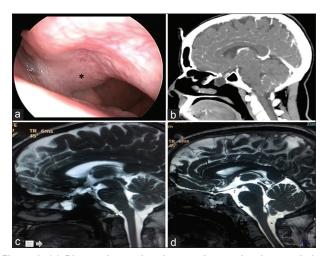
(a) Diagnostic nasal endoscopy image showing persisting embryonal infundibular recess presenting as a nasal mass in the superior nasopharynx (*). (b) Contrast computed tomography brain showing a cystic lesion herniating through a bony defect anterior to shallow sella. (c) Preoperative magnetic resonance imaging constructive interference in steady state sequence showing the communication of the third ventricular floor with the cyst through a persistent embryonal infundibular recess. (d) Postoperative magnetic resonance imaging constructive interference in steady state sequence showing reduction of the sac and reconstruction of the defect
